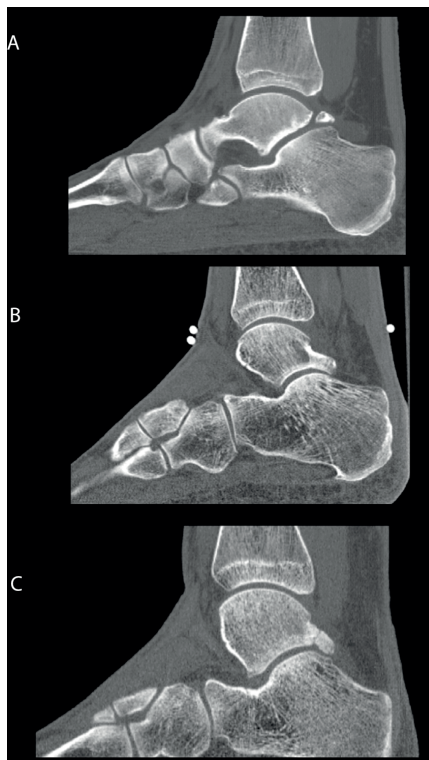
Sagittal CT images of the ankle. A. Os trigonum. B. Hypertrophic lateral tubercle of the posterior talar process (Stieda's process). C. Fracture of the lateral tubercle of the posterior talar process (Shepherd's fracture).
